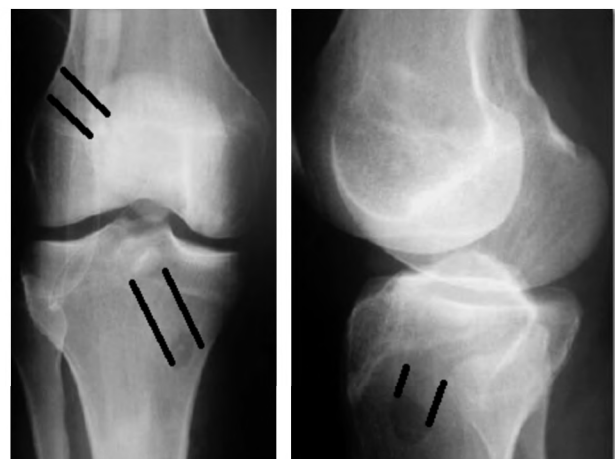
Immediate post operative X-ray AP & lat.
